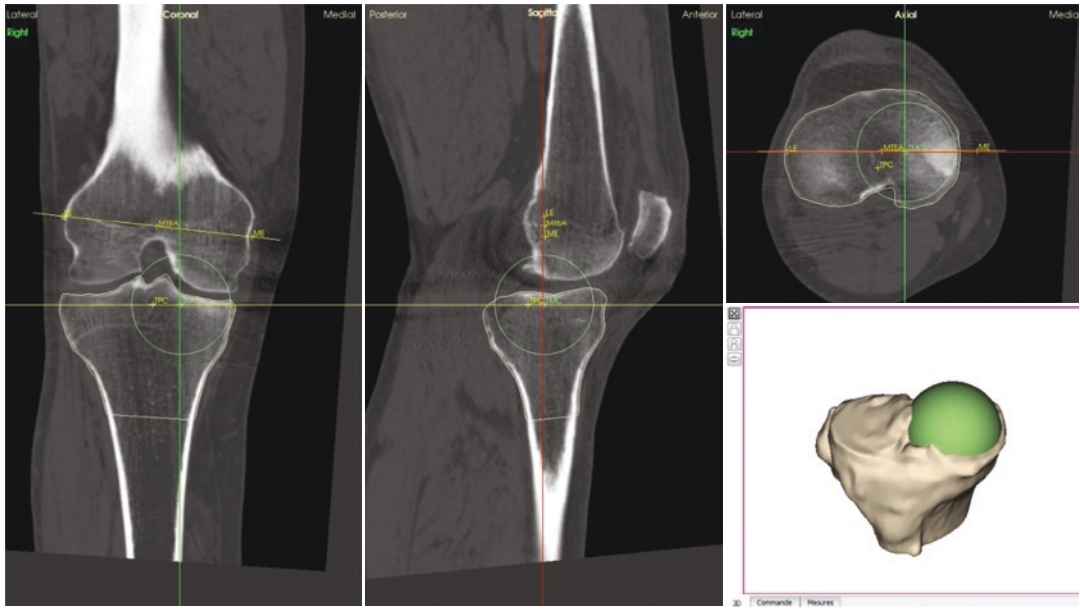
CT slices of a patient's knee and a sphere placed on the medial tibial condyle
